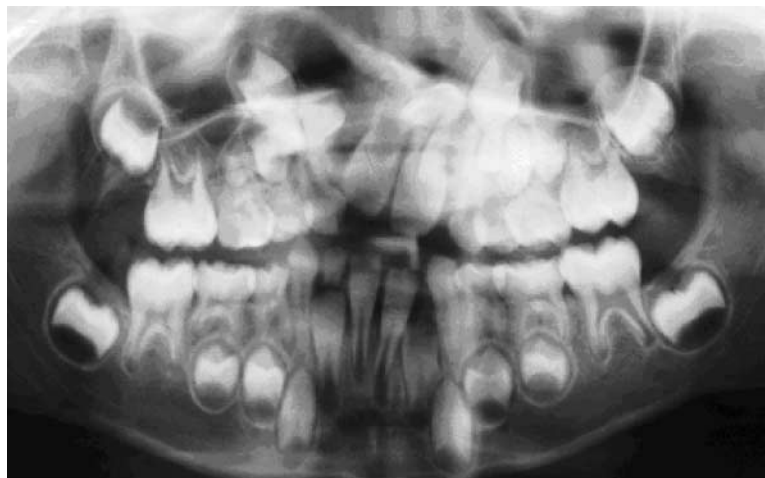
Patient B. Panoramic radiograph with blurred imaging of a mesiodens in the region of the cleft
